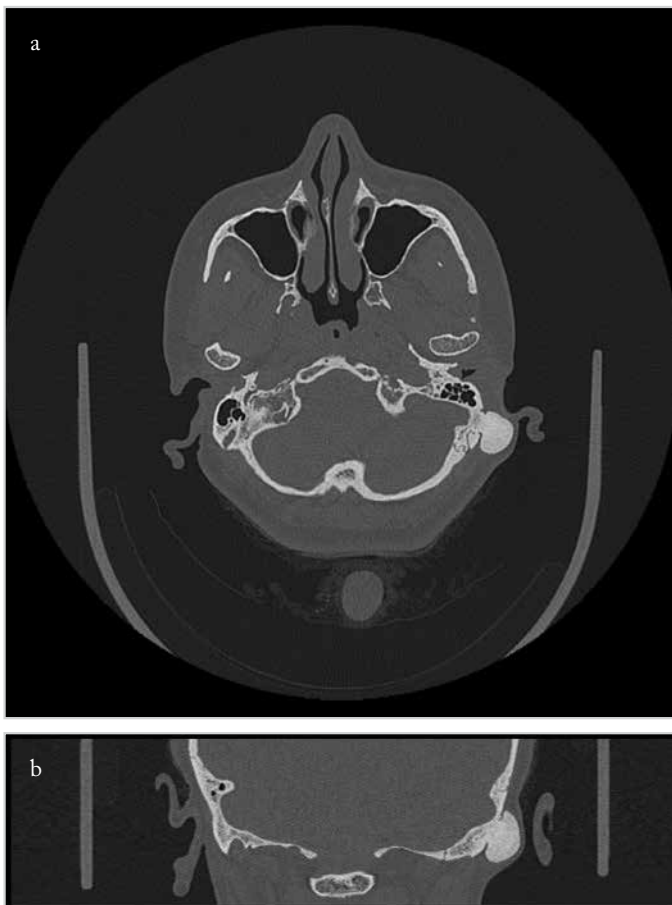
(a) Temporal bone CT (axial section); (b) temporal bone CT (coronal section)
